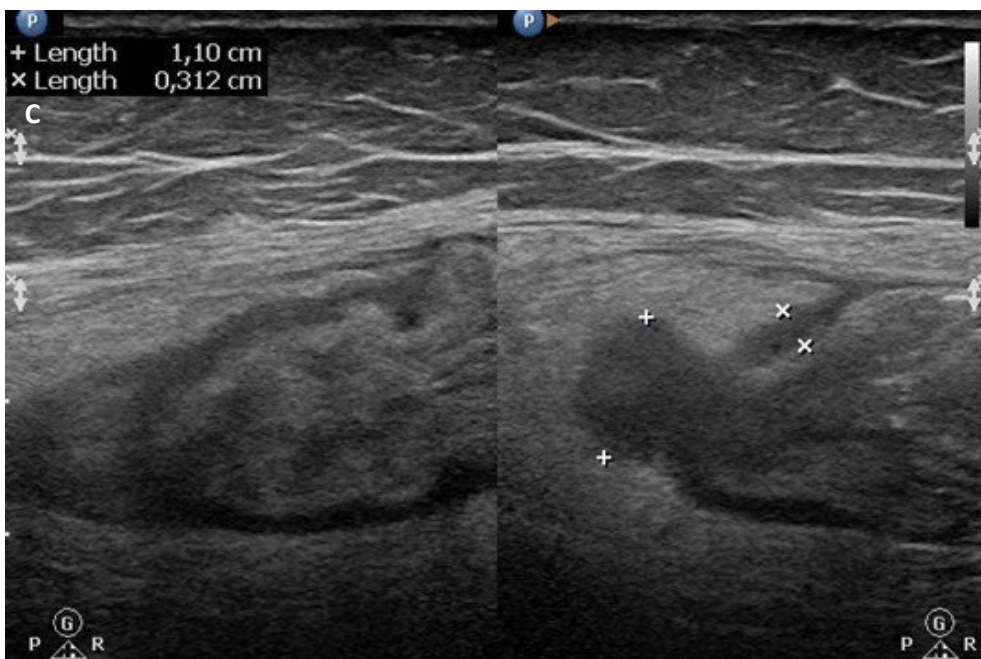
C – Signs of acute diverticulitis on ultrasound – hypochoic diverticulum with swelling of adjacent fat
